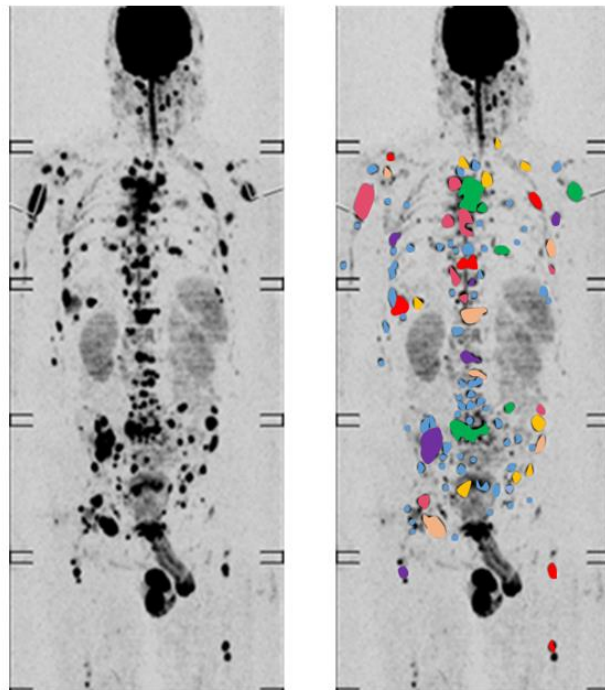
CT-image displaying the intra-tumor heterogeneity in multiple myeloma (MM). Colored spots indicate the presence of different focal lesions identified by multi-region sequencing of CT-guided fine needle aspirates [18].
